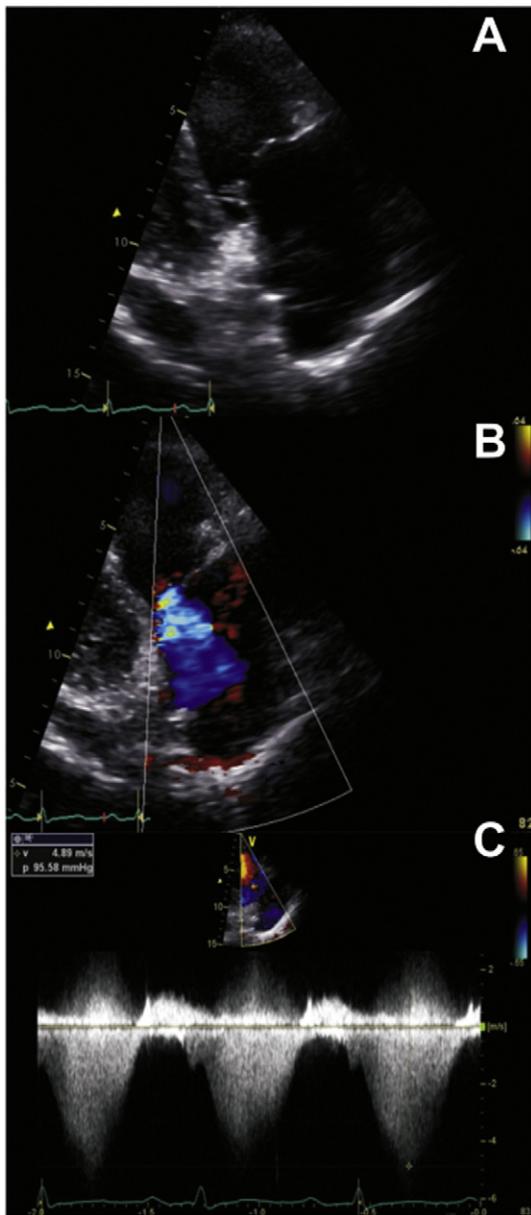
Mildly thickened tricuspid valve leaflets (A: right ventricular inflow view on transthoracic echocardiography), with significant tricuspid regurgitation (B: color Doppler analysis in right ventricular inflow view on transthoracic echocardiography). Estimated right ventricular systolic pressure was severely elevated (C: continuous wave Doppler recording through tricuspid regurgitant signal in right ventricular inflow view on transthoracic echocardiography).
